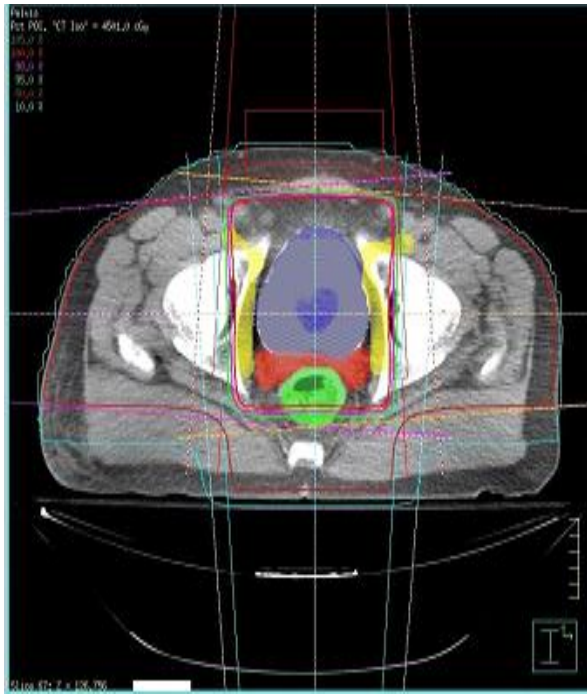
Adjustment of the computed tomography (CT) iso-center and the Clinac iso-center, and the beam's eye view in the radiation therapy treatment planning using field segmentations with 40 pairs of multi-leaf collimators (MLCs) and non-uniform beam collimation technique.
